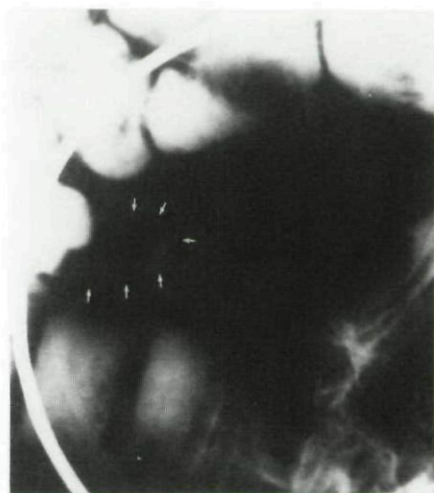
Barium outlining a diverticular pouch (arrows) on small bowel radiography.
